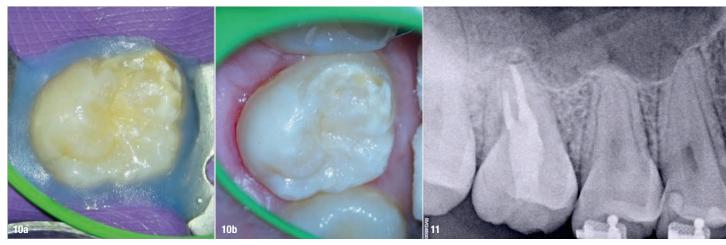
Final radiograph of the root canal therapy and coronal restoration. Placing the coronal filling material into the pulp chamber tends to be complex with such a small access opening.
